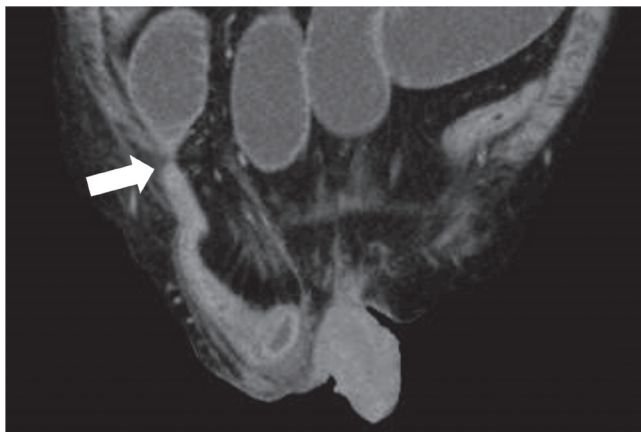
Abdominal CT scan showing a caliber change of the small intestine starting at the site of an inguinal hernia (white arrow) without evidence of ischemia
